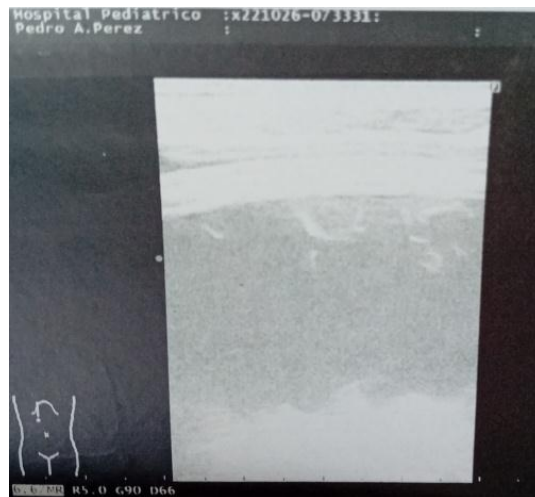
Chest ultrasound
